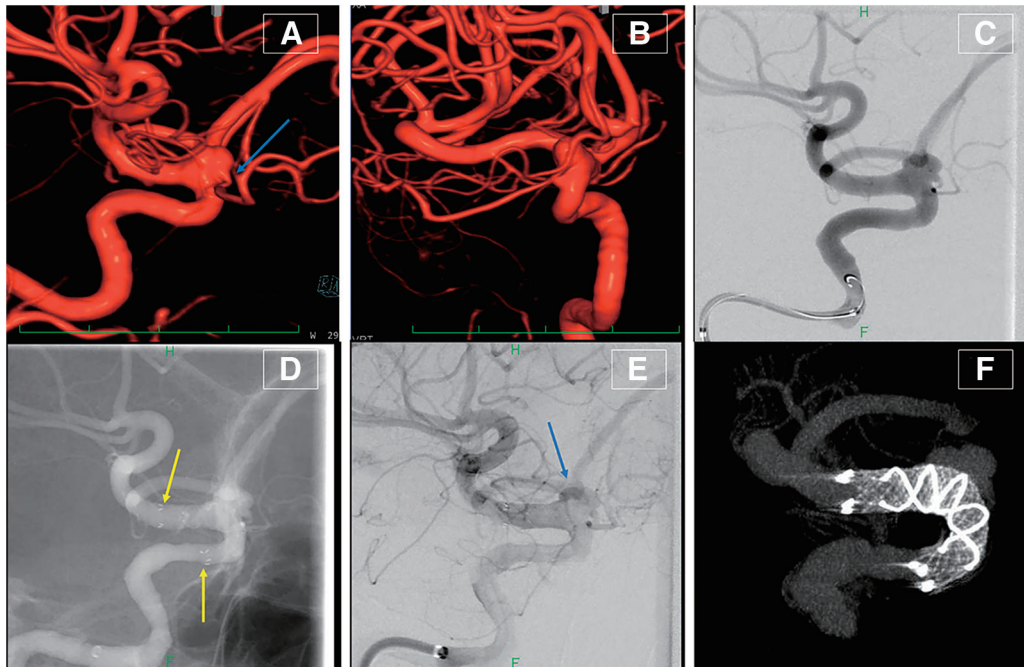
A 50-year-old woman with an unruptured internal carotid–ophthalmic artery aneurysm. The maximum size and neck size of the aneurysm was 8.0 mm and 4.9 mm, respectively. The ophthalmic artery (blue arrow in A) branched from the dome of the aneurysm. (A and B) Initial 3D reconstruction of DSA and (C) DSA in the working angle. Based on the diameter of the ICA proximal (3.8 mm) and distal (3.6 mm) to the aneurysm, a 4.0-mm-diameter and 18-mm-long FRED was deployed across the neck of the aneurysm. The yellow arrows indicate the distal and proximal flared ends of the FRED, respectively (D). Post-deployment angiography revealed a little intra-aneurysm contrast stagnation (blue arrow) after the treatment. (E). Except for the proximal part (proximal flair) of the FRED, complete expansion of the FRED was confirmed using cone-beam CTA (F). FRED: flow-redirection endoluminal device; ICA: internal carotid artery
